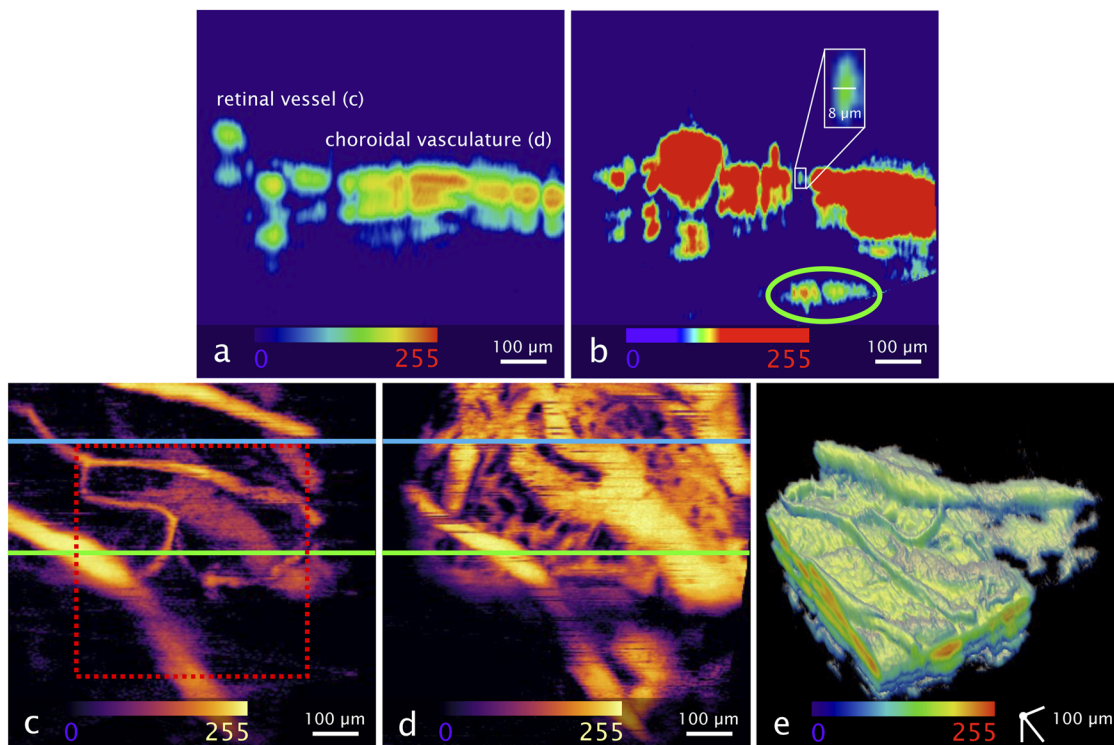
Rose Bengal PAOM imaging. (a) A typical PAOM B-scan. (b) Contrast adjusted PAOM B-scan with unobstructed scleral features (green ellipse). (c) and (d) En face projections of the same volume at different depths for the retinal (c) and choroidal (d) layers, respectively. Dotted red square: active area of the ultrasound transducer. Blue line: B-scan position of (a). Green line: B-scan position of (b). (e) Volumetric rendering depicting the retinal vasculature on top of the choroid. The scale bar for (a)–(d) is valid for all spatial directions.
